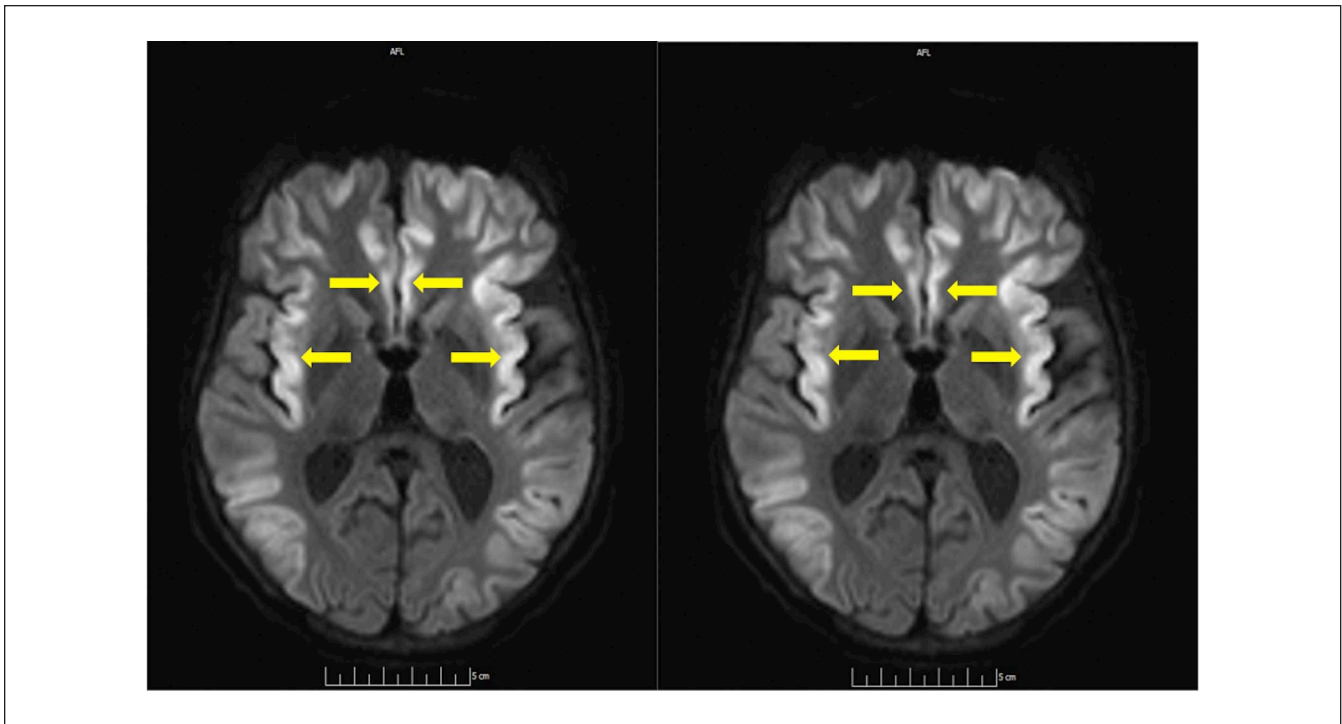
Diffusion-weighted imaging (DWI), with extensive restricted diffusion in cortex, including cingulate and insular cortices (yellow arrows) typically seen with elevated ammonia levels.
